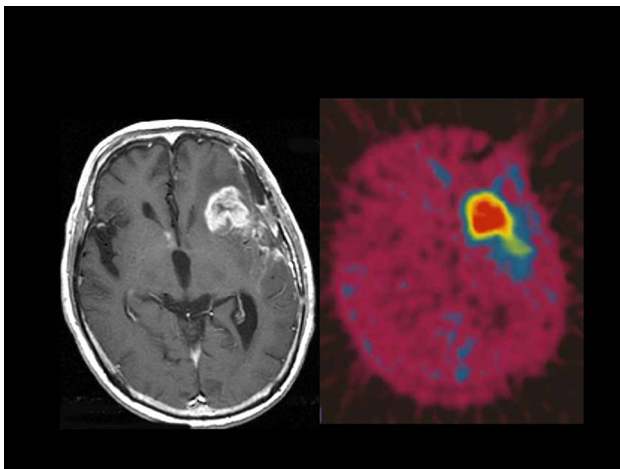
Contrast-enhanced T1-weighted MRI ^{18}F -labeled BPA-PET image of a representative glioblastoma (GBM) patient. The patient received ^{18}F -BPA-PET to assess the distribution of boronophenylalanine (BPA) and to estimate the boron concentration in the tumor before BNCT without a direct determination of the boron concentration in the tumor. The lesion-to-normal brain (L/N) ratio of the enhanced tumor was 7.8 in this case. Note that even the periphery of the main mass (i.e., the infiltrative portion of the tumor) showed BPA uptake. The L/N ratio of the BPA uptake was estimated from this study and then used for the dose planning. ^{18}F -BPA-PET provided an accurate estimate of the accumulation and distribution of BPA
